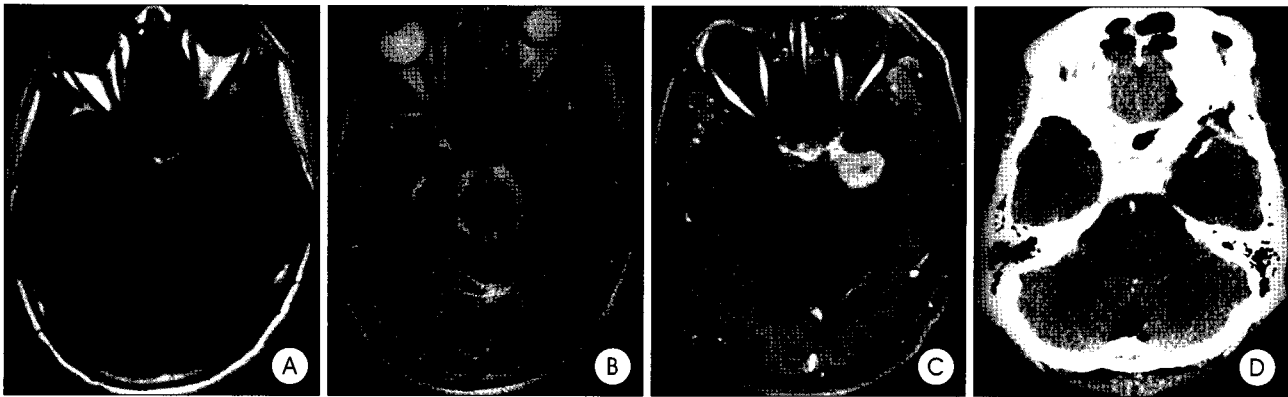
Magnetic resonance image indicating a 2.5×2.5cm sized, heterogeneously contrast enhancing mass which attached to left cavernous sinus extending to left temporal lobe without peritumoral edema (A–C). Elective left frontotemporal craniotomy with orbital osteotomy is done. The tumor mass is originated from the posterior portion of left cavernous sinus and penetrated through adjacent dura mater with intradural growth. Total removal of the tumor mass (Simpson grade II) is performed (D).
